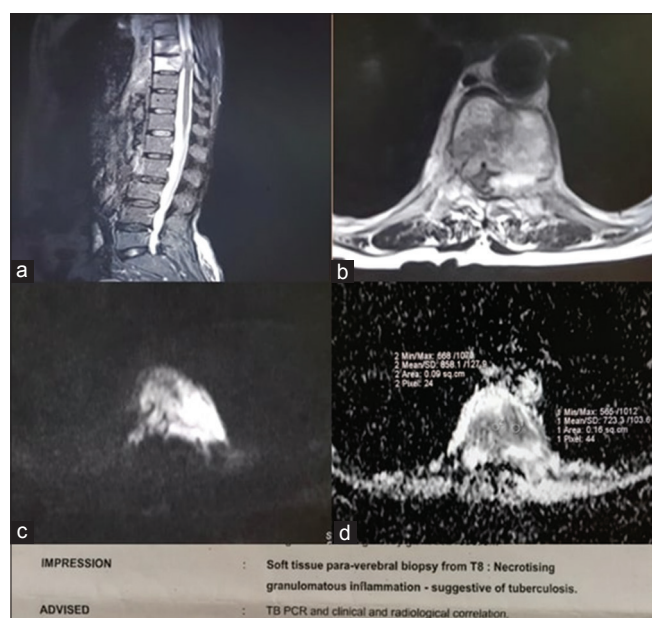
A 61-year-old female presented with bilateral paraplegia. (a) Sagittal T2-weighted imaging (WI) shows heterogeneous hyperintensity in T8/9 vertebrae. (b) Axial T2 WI at the level of T9 vertebrae shows expansion with increased signal intensity with the involvement of posterior elements and cord compression. (c) Axial diffusion-weighted image at same level shows diffusion restriction. (d) Corresponding axial apparent diffusion coefficient (ADC) map ($b = 0$ and 1000 s/mm^2 shows decreased signal intensity with an ADC value of 0.0.79 in bone and 0.94 in soft tissue component). [Biopsy revealed granulomatous inflammation suggestive of tuberculosis]
